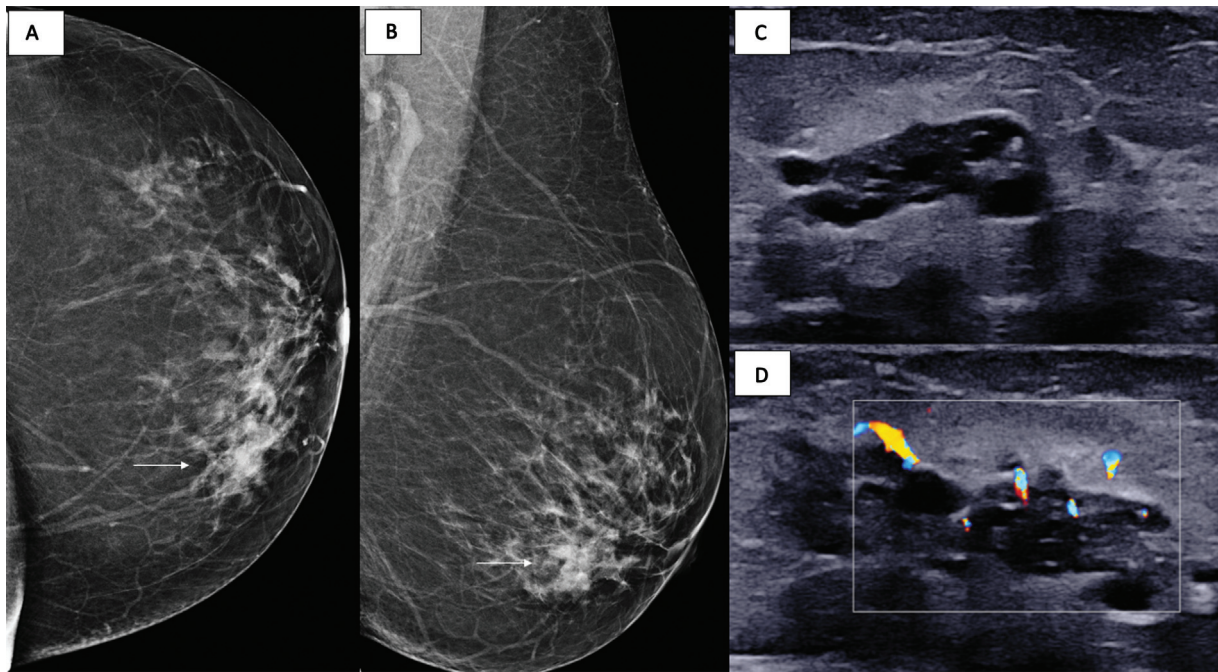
Residual breast abscess sequelae as nonmass finding. Mediolateral oblique and craniocaudal mammographic views show an equal density mass with indistinct margins in the lower inner quadrant (arrows in A & B). Correlative ultrasound shows a hypoechoic nonmass lesion with peripheral vascularity and internal cystic areas and septations (C & D). The patient had a history of abscess with aspiration of pus from the same site few months back.
